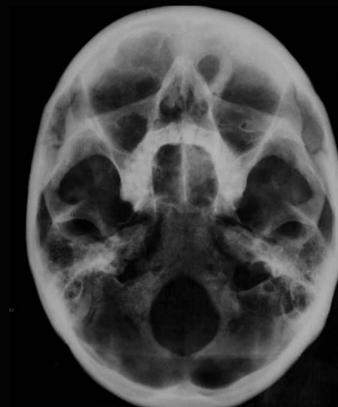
Radiograph (inferior view) of case 82/01 presenting lesion of left orbitofrontal. Note absence of left frontal sinus.
